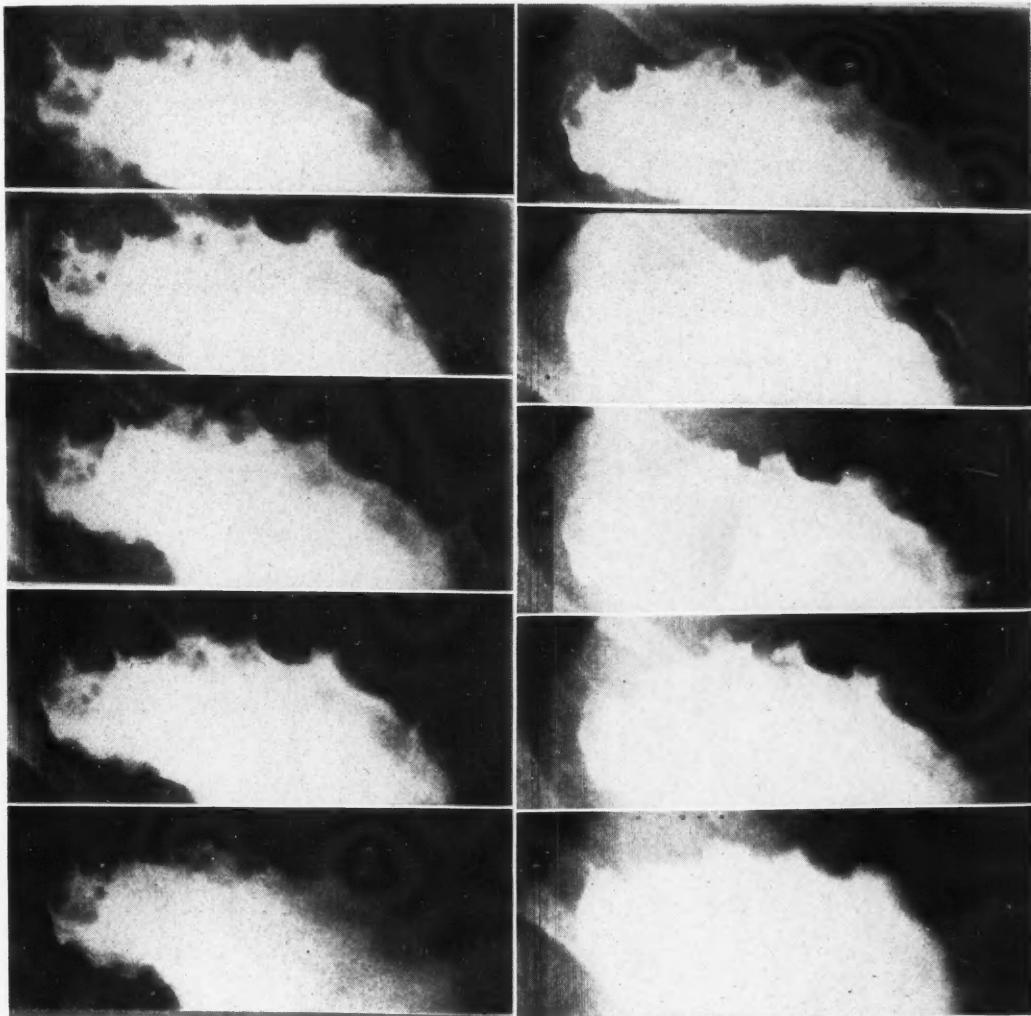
Serial roentgenographs (taken at 1 second intervals) of the fundus of a barium filled stomach, taken with the patient supine and holding his breath. The fundus was studied because of the absence of circular peristaltic waves. Note the changes in contour of the mucosal pattern caused by the muscularis mucosae.
